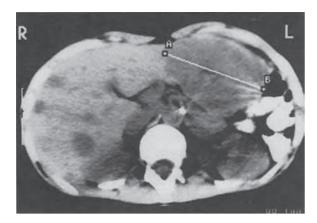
CT scan of recurrent malignant phaeochromocytoma in the left adrenal tumour bed. Multiple metastases are seen in the right lobe of the liver.
